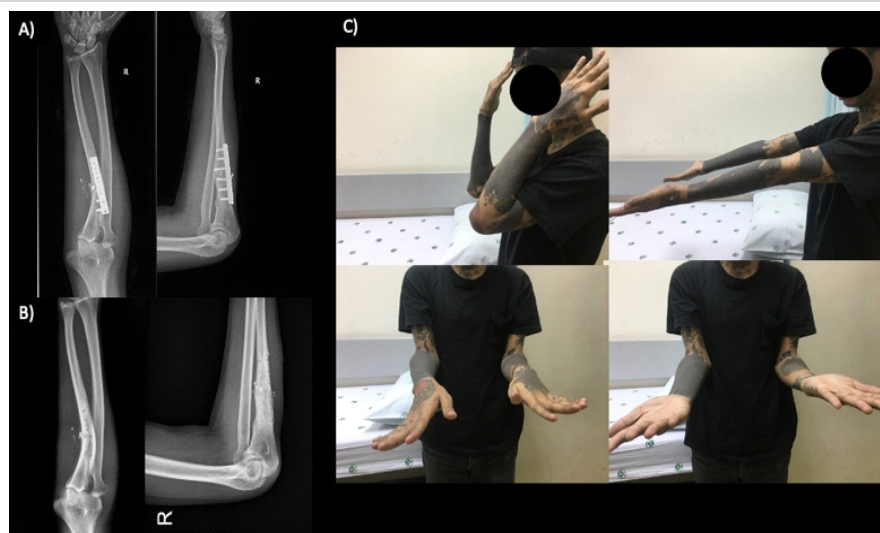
Anteroposterior and lateral radiograph of affected forearm pre- (a) and post-implant removal (b); (c) Clinical pictures of forearm range of motion.
